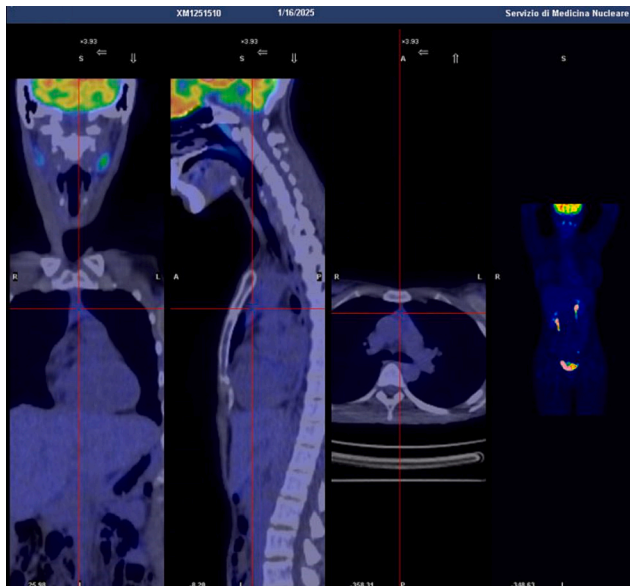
PET/CT scan at the last follow-up 6 months after tertiary cytoreductive surgery. Images revealed no evidence of abnormal tracer accumulation in the examined body regions that could be associated with high metabolic activity disease locations.
